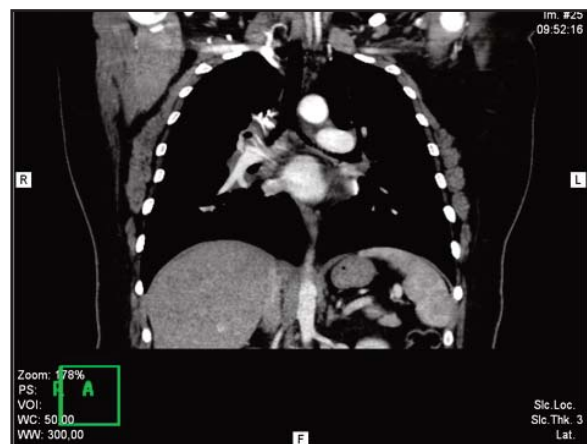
This section of computed tomography shows mediastinal lymphadenopathy.
